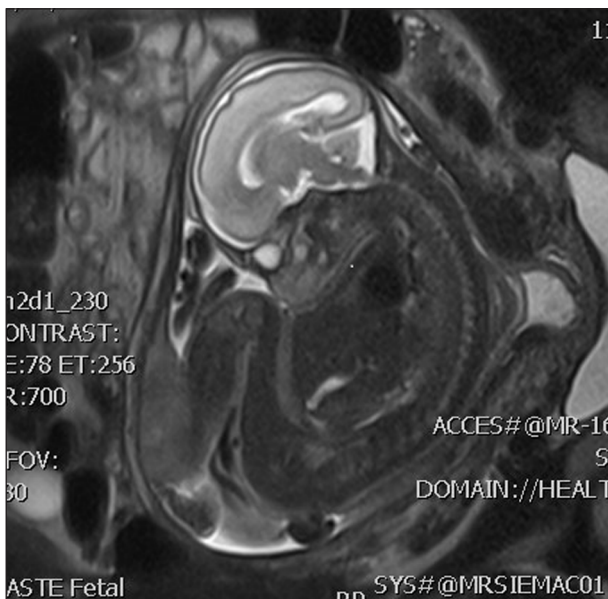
Fetal MRI showed well-defined lesion at the midline of the back, superficial to the mid and lower thoracic spine.
